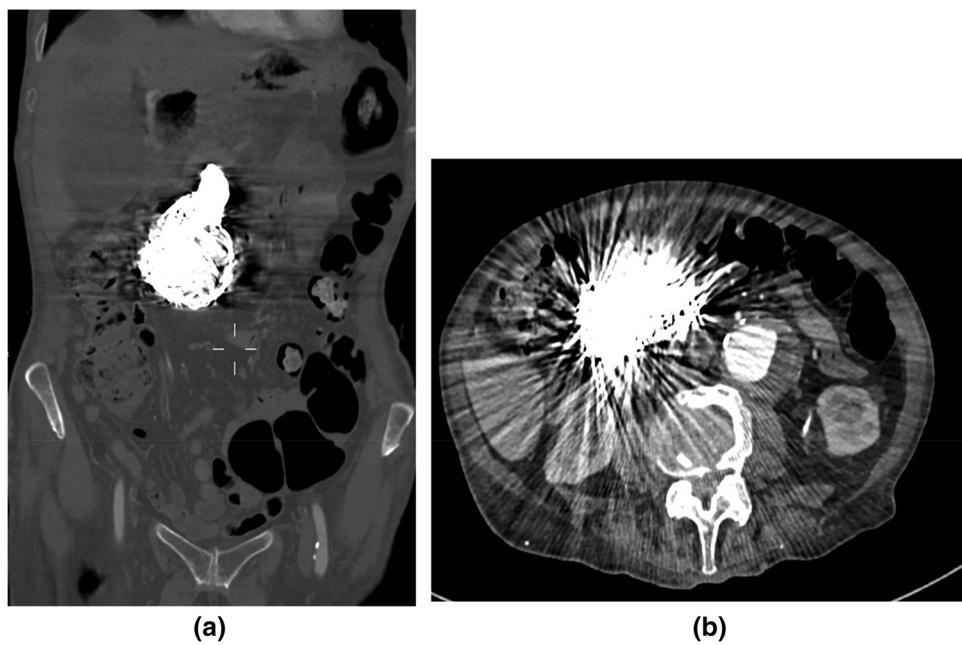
Follow-up CT scan performed 3 days after the procedure. CT imaging confirming, in coronal (a) and axial (b) reconstructions, successful endovascular embolisation with multiple metallic microcoils and no opacification of the giant pseudoaneurysm's sac and its in-flow tract.
